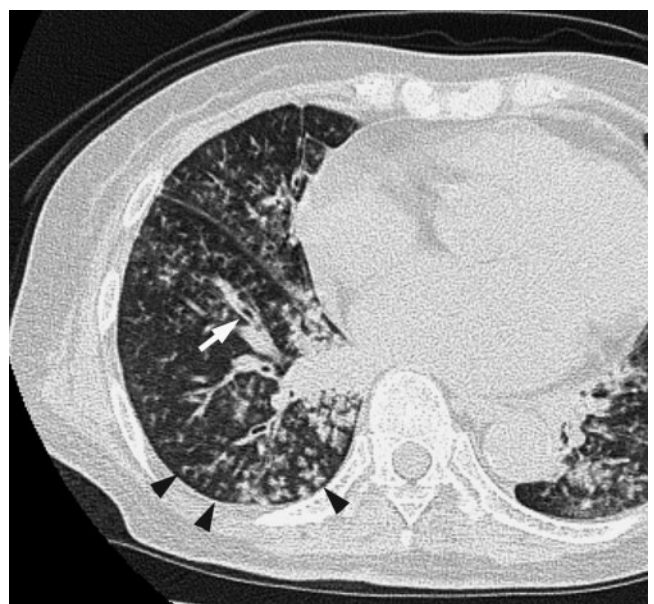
Acute *Moraxella catarrhalis* infection in a 42-year-old alcoholic male with diabetes mellitus, 2 days after onset of fever and cough with sputum. A transverse thin-section CT of the right upper lobe shows consolidation, ground-glass opacity, bronchial wall thickening (arrowhead) and centrilobular nodules (arrow).
